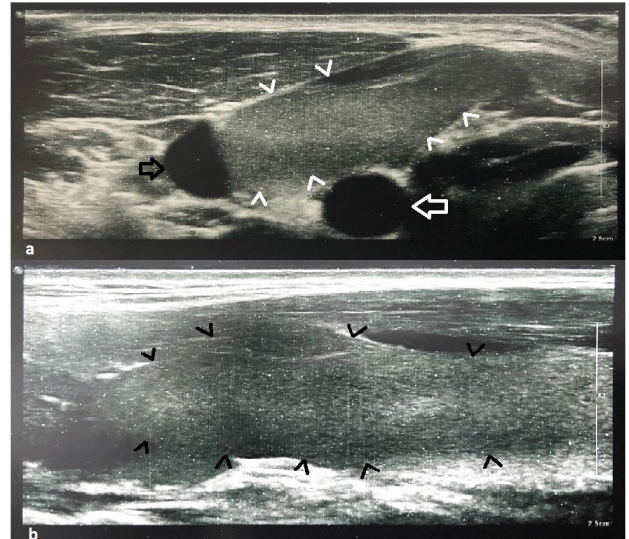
Ultrasound images of cervical lesion in transverse (a) and longitudinal (b) planes. (White arrow: Common Carotid Artery, Black Arrow: Jugular Vein, White and Black Arrowheads: Lymphangioma)
